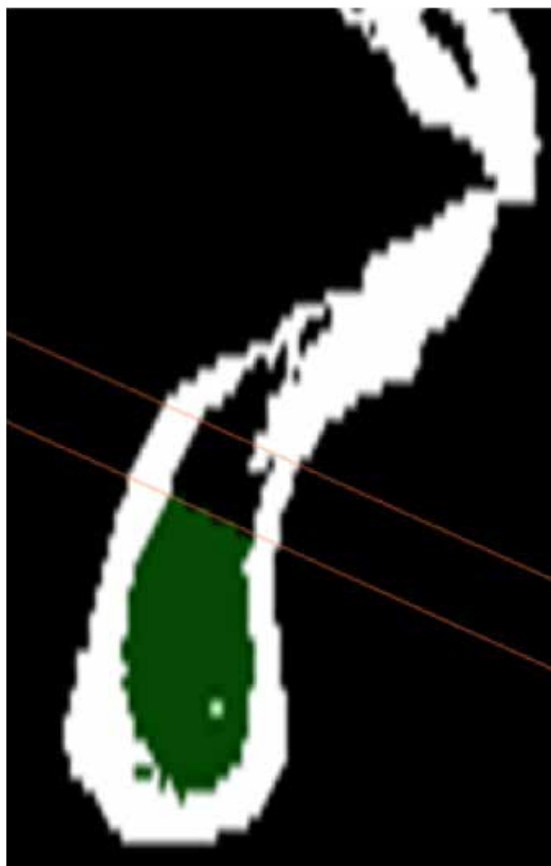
Mid-sagittal slices of a C-mode CBCT image; total basal cancellous bone density.
